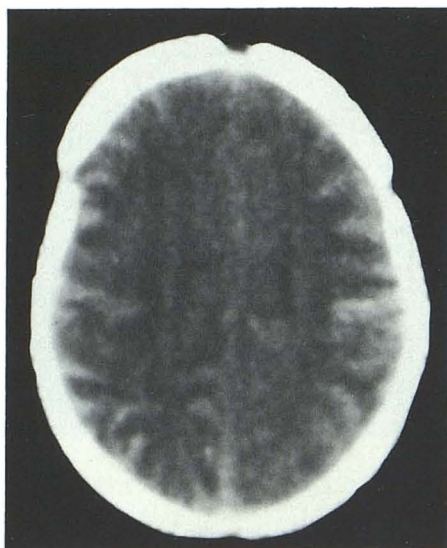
27-day-old infant. Unenhanced CT scans at 12 days after presentation. Intense cortical gyral density.
